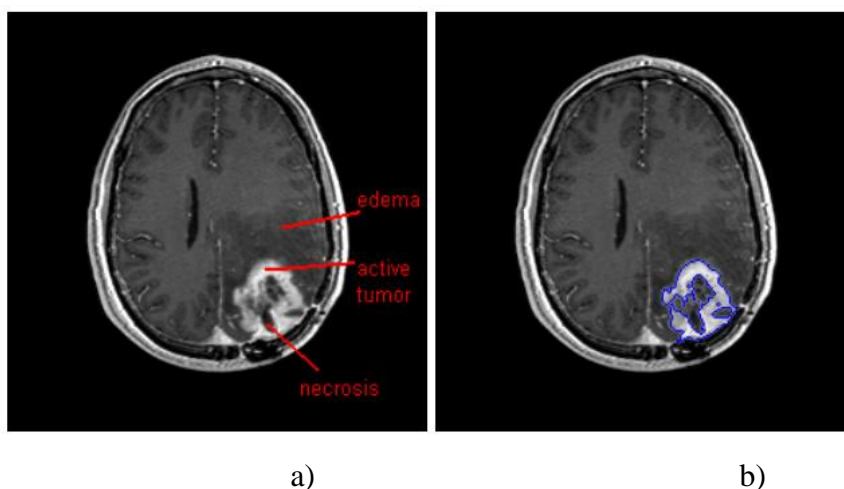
GBM brain tumor: a) the tumor presentation on a T1w post contrast MR image slice; b) the tumor contour drawn by a neuroradiologist
